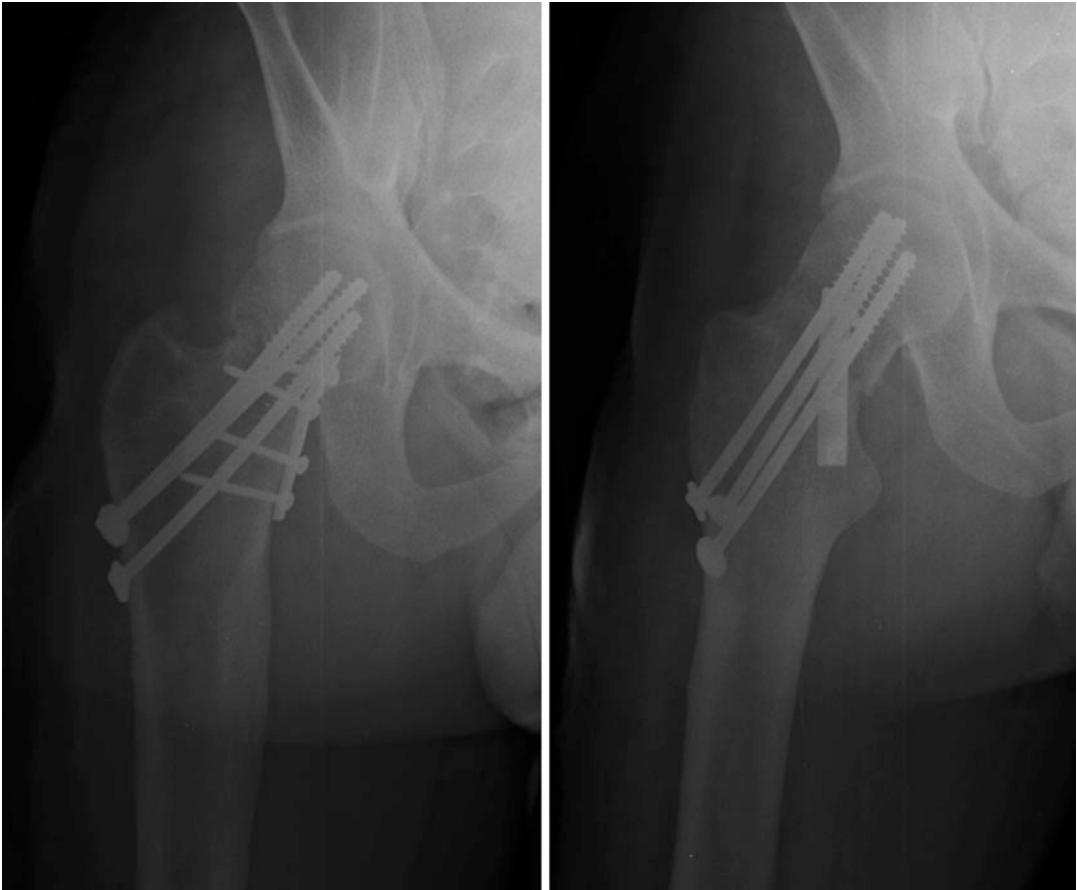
X-ray of the fixation of the femoral neck fracture with cannulated screws and medial buttress plate
